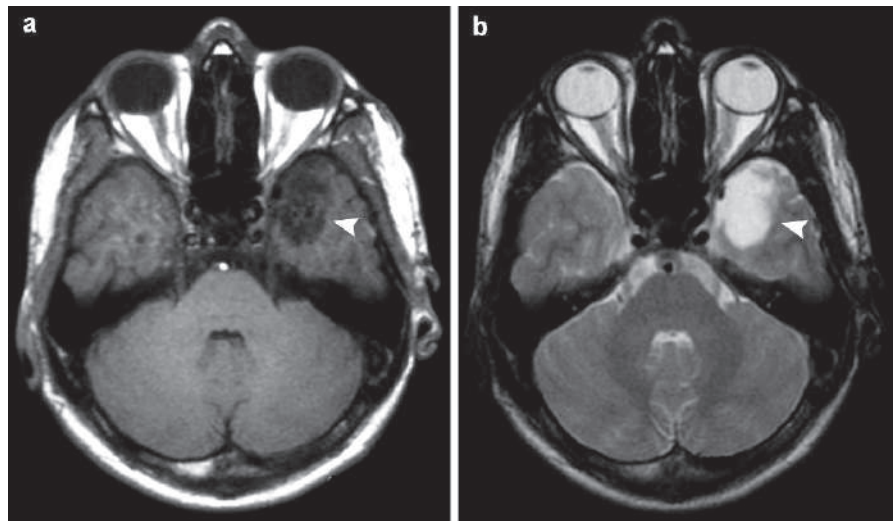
Axial T1W postcontrast (a) and T2W (b) brain MRI in a patient with epilepsy show temporal cortical hypointense lesion with high T2 signal intensity and no contrast enhancement (desmoplastic neuroepithelial tumor)
